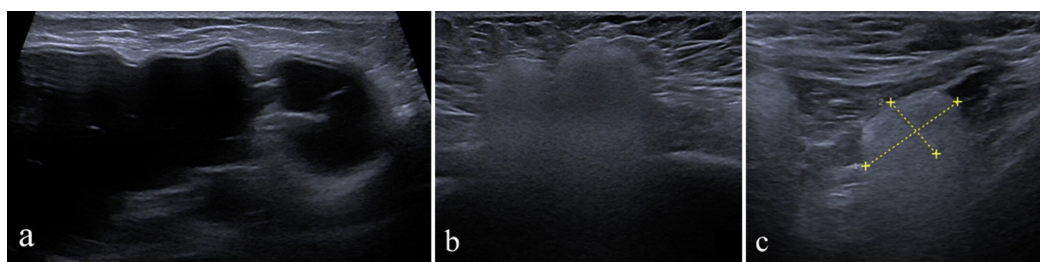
Ultrasound assessment of the silicone breast implant. Image a: heterogeneous prosthetic content along the inner aspect of the implant. Image b: hyperechoic pseudonodular lesion adjacent to the external surface of the implant, demonstrating a snowstorm sign, suggestive of a siliconoma versus an intramammary lymph node containing silicone. Image c: axillary lymph node with silicone deposition, also demonstrating a snowstorm appearance.
